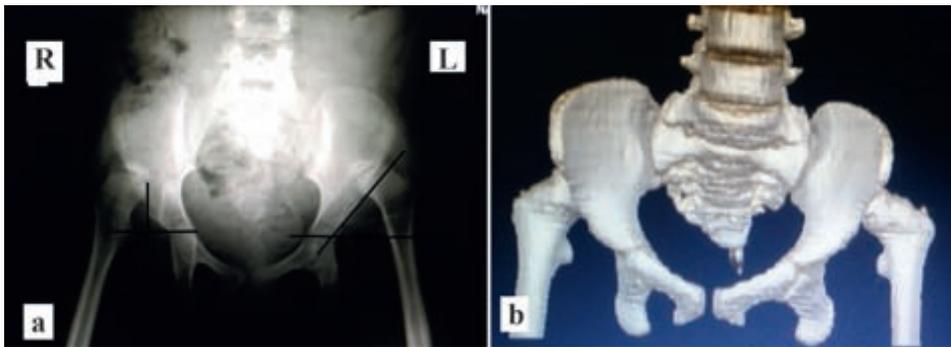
(a) X-ray of pelvis with both hips showing dislocated hip on both sides. Head of femur in superolateral quadrant formed by Hilgenreiner's and Perkin's lines (shown on the right side). Acetabular index was nearly 45° (shown on the left side). Shenton's line is broken on both sides. (b) CT showing similar picture with shallow acetabulum on both sides.
